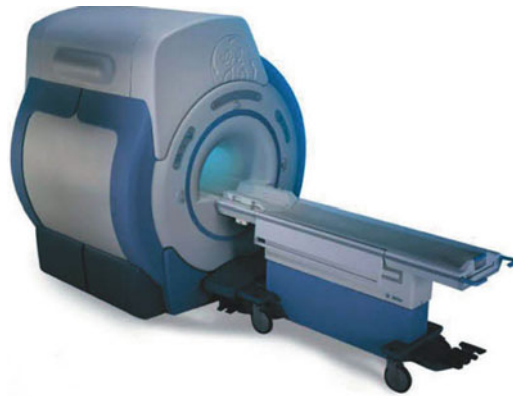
A typical MRI scanner
